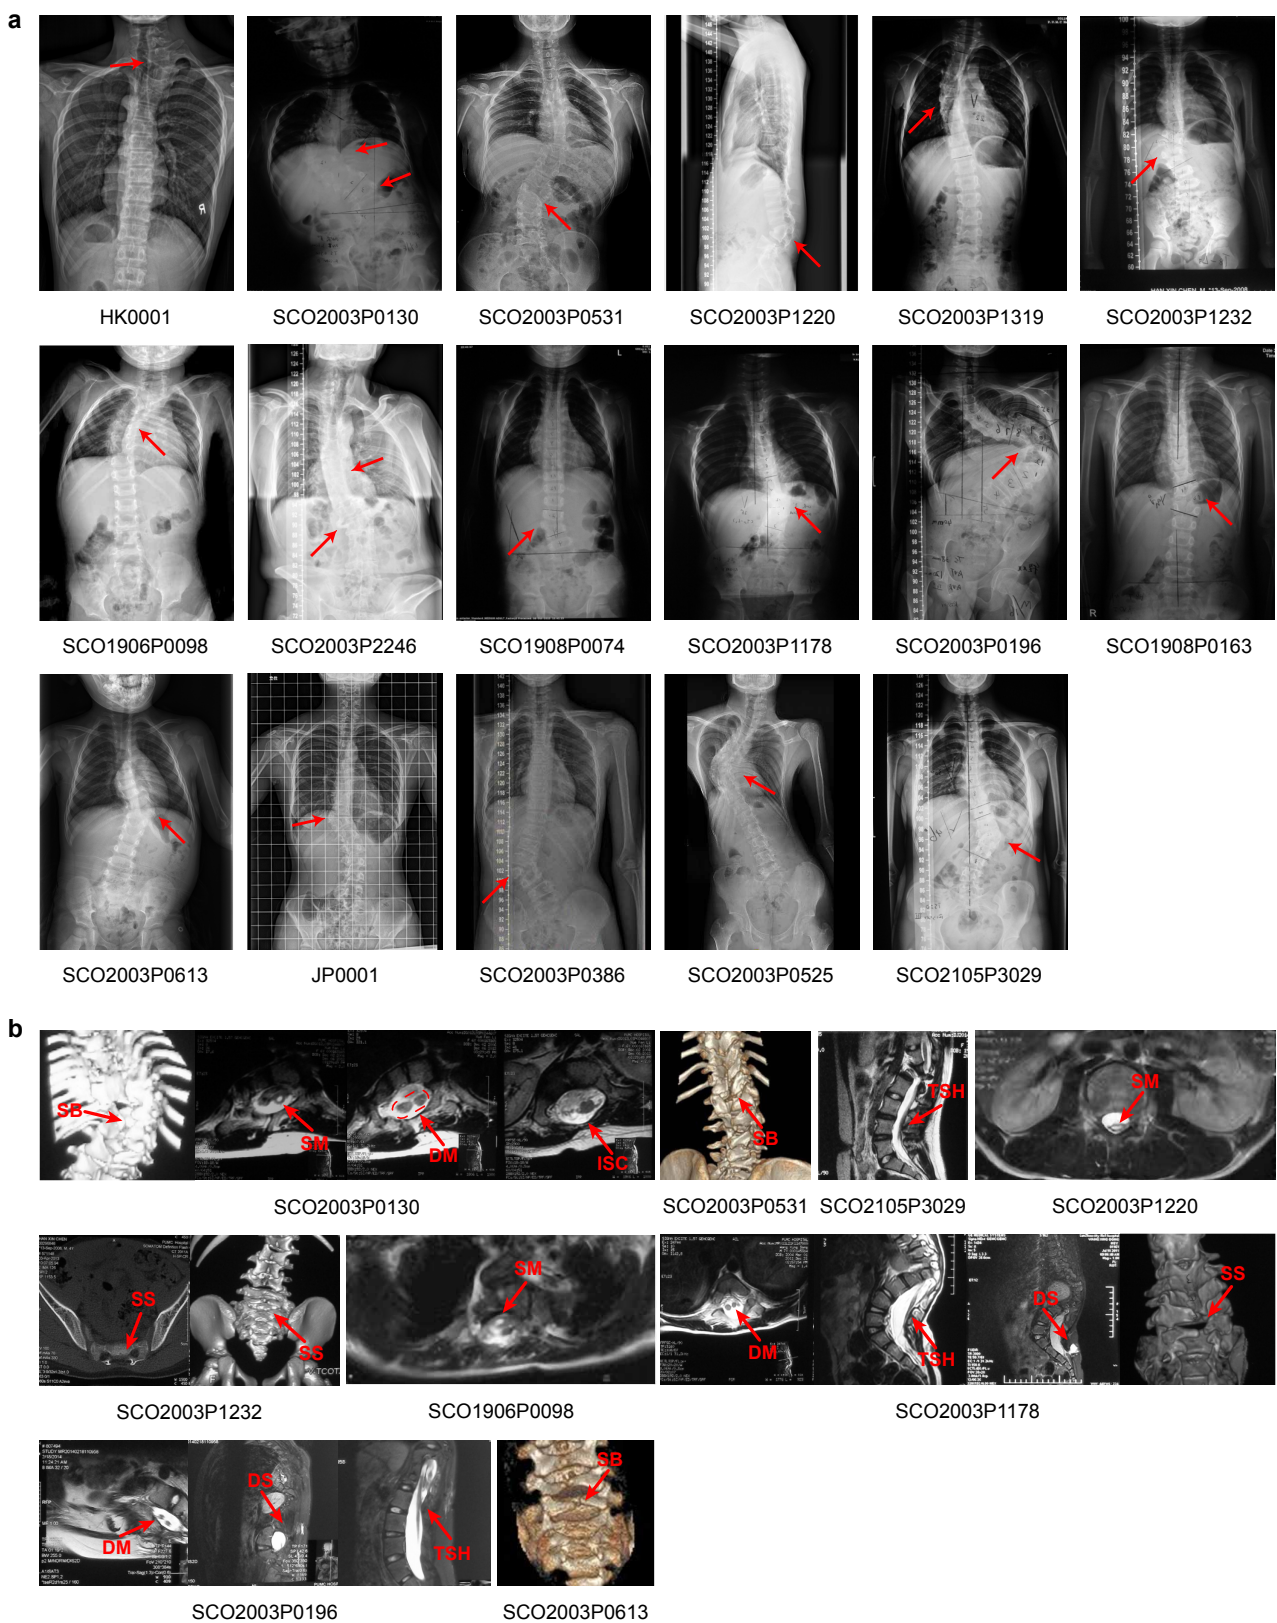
Clinical images of patients with *VANGL1* and *VANGL2* variants. a Spinal X-ray. All patients present different severity of spine deformities, ranging from one vertebral malformation (single-segmented hemivertebrae) to extensive fusion of vertebrae. b Intraspinal abnormalities and spinal lamina defects demonstrated by CT or MRI of the spine. Intraspinal abnormalities and spinal lamina defects were commonly seen in CS patients with *VANGL1* and *VANGL2* variants. The vertebral and intraspinal malformations are indicated by red arrows. Abbreviations: SM, syringomyelia; DM, diastematomyelia; ISC, intraspinal cyst; SB, spinal bifida; TSH, tethered spinal cord; SS, sacral schisis; DS, dermal sinus.
